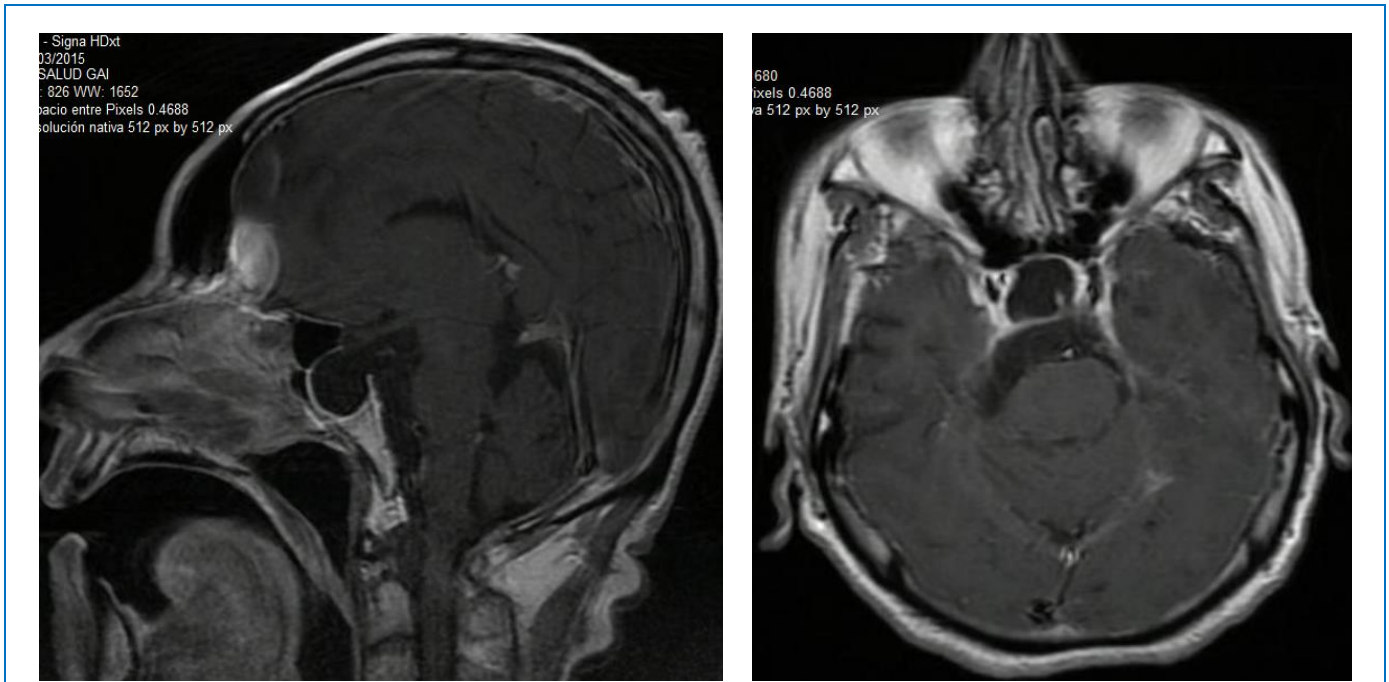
Magnetic resonance imaging (MRI) with gadolinium in sagittal and axial sections, prior to peritoneal ventricular bypass surgery, showing enlarged sella turcica apparently filled with cerebrospinal fluid covering almost the entire sphenoid sinus.
